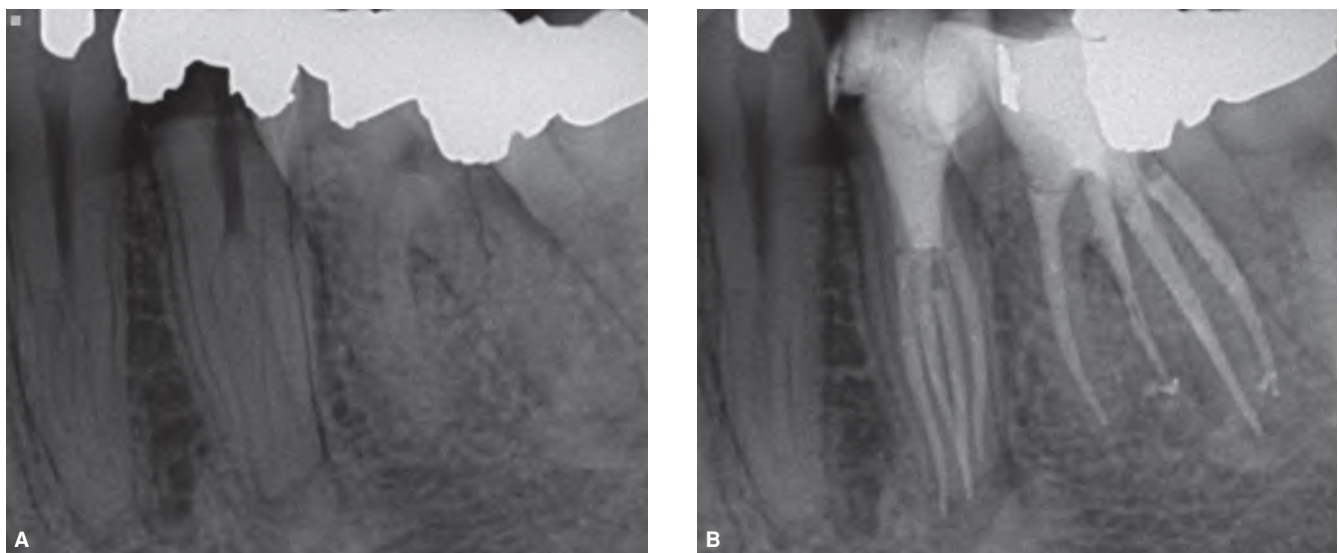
Supernumerary root canals in a mandibular second premolar of a 21-year-old female diagnosed with irreversible pulpitis and symptomatic apical periodontitis. A. Preoperative radiograph. B. Immediate postoperative radiograph showing 4 root canals. Canal orifice distribution was one buccal, one lingual, and two middle (one mesial and one distal). (Courtesy of Dr. Taoheed O. Johnson, Advanced Endodontics Program, University of Southern California, Los Angeles, CA.)
